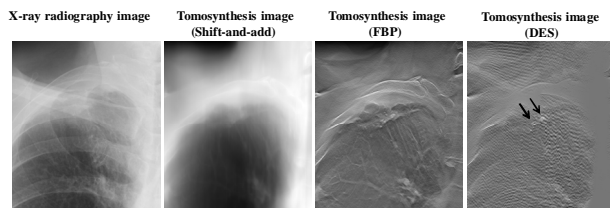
Patient (74-year-old man; calcified tuberculous foci). Comparison of chest images obtained using X-ray radiography, shift-add tomosynthesis, conventional digital tomosynthesis, and dual-energy subtraction digital tomosynthesis. For detection of calcifications in pulmonary nodules, dual-energy subtraction tomosynthesis proved better than any other modality imaging methods.
